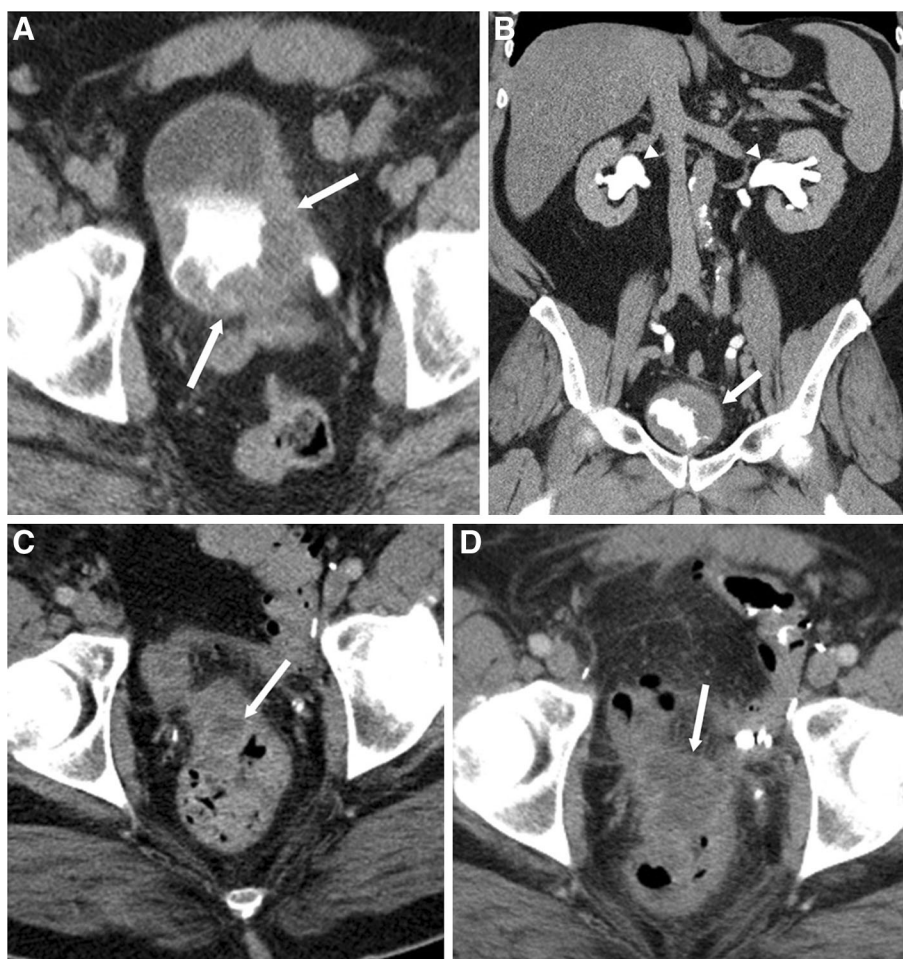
54-year-old man with 6-month history of gross hematuria and diagnosis of high-grade invasive papillary urothelial carcinoma, and subsequent local recurrence after surgery. A, B Axial and coronal CT urogram images in the excretory phase at diagnosis show irregular thickening of the posterior and lateral bladder wall with bilateral ureterovesical junction obstruction (*white arrows A*) causing hydronephrosis (*arrowheads B*). C First postoperative axial CT image 3 months after radical cystectomy revealed a
